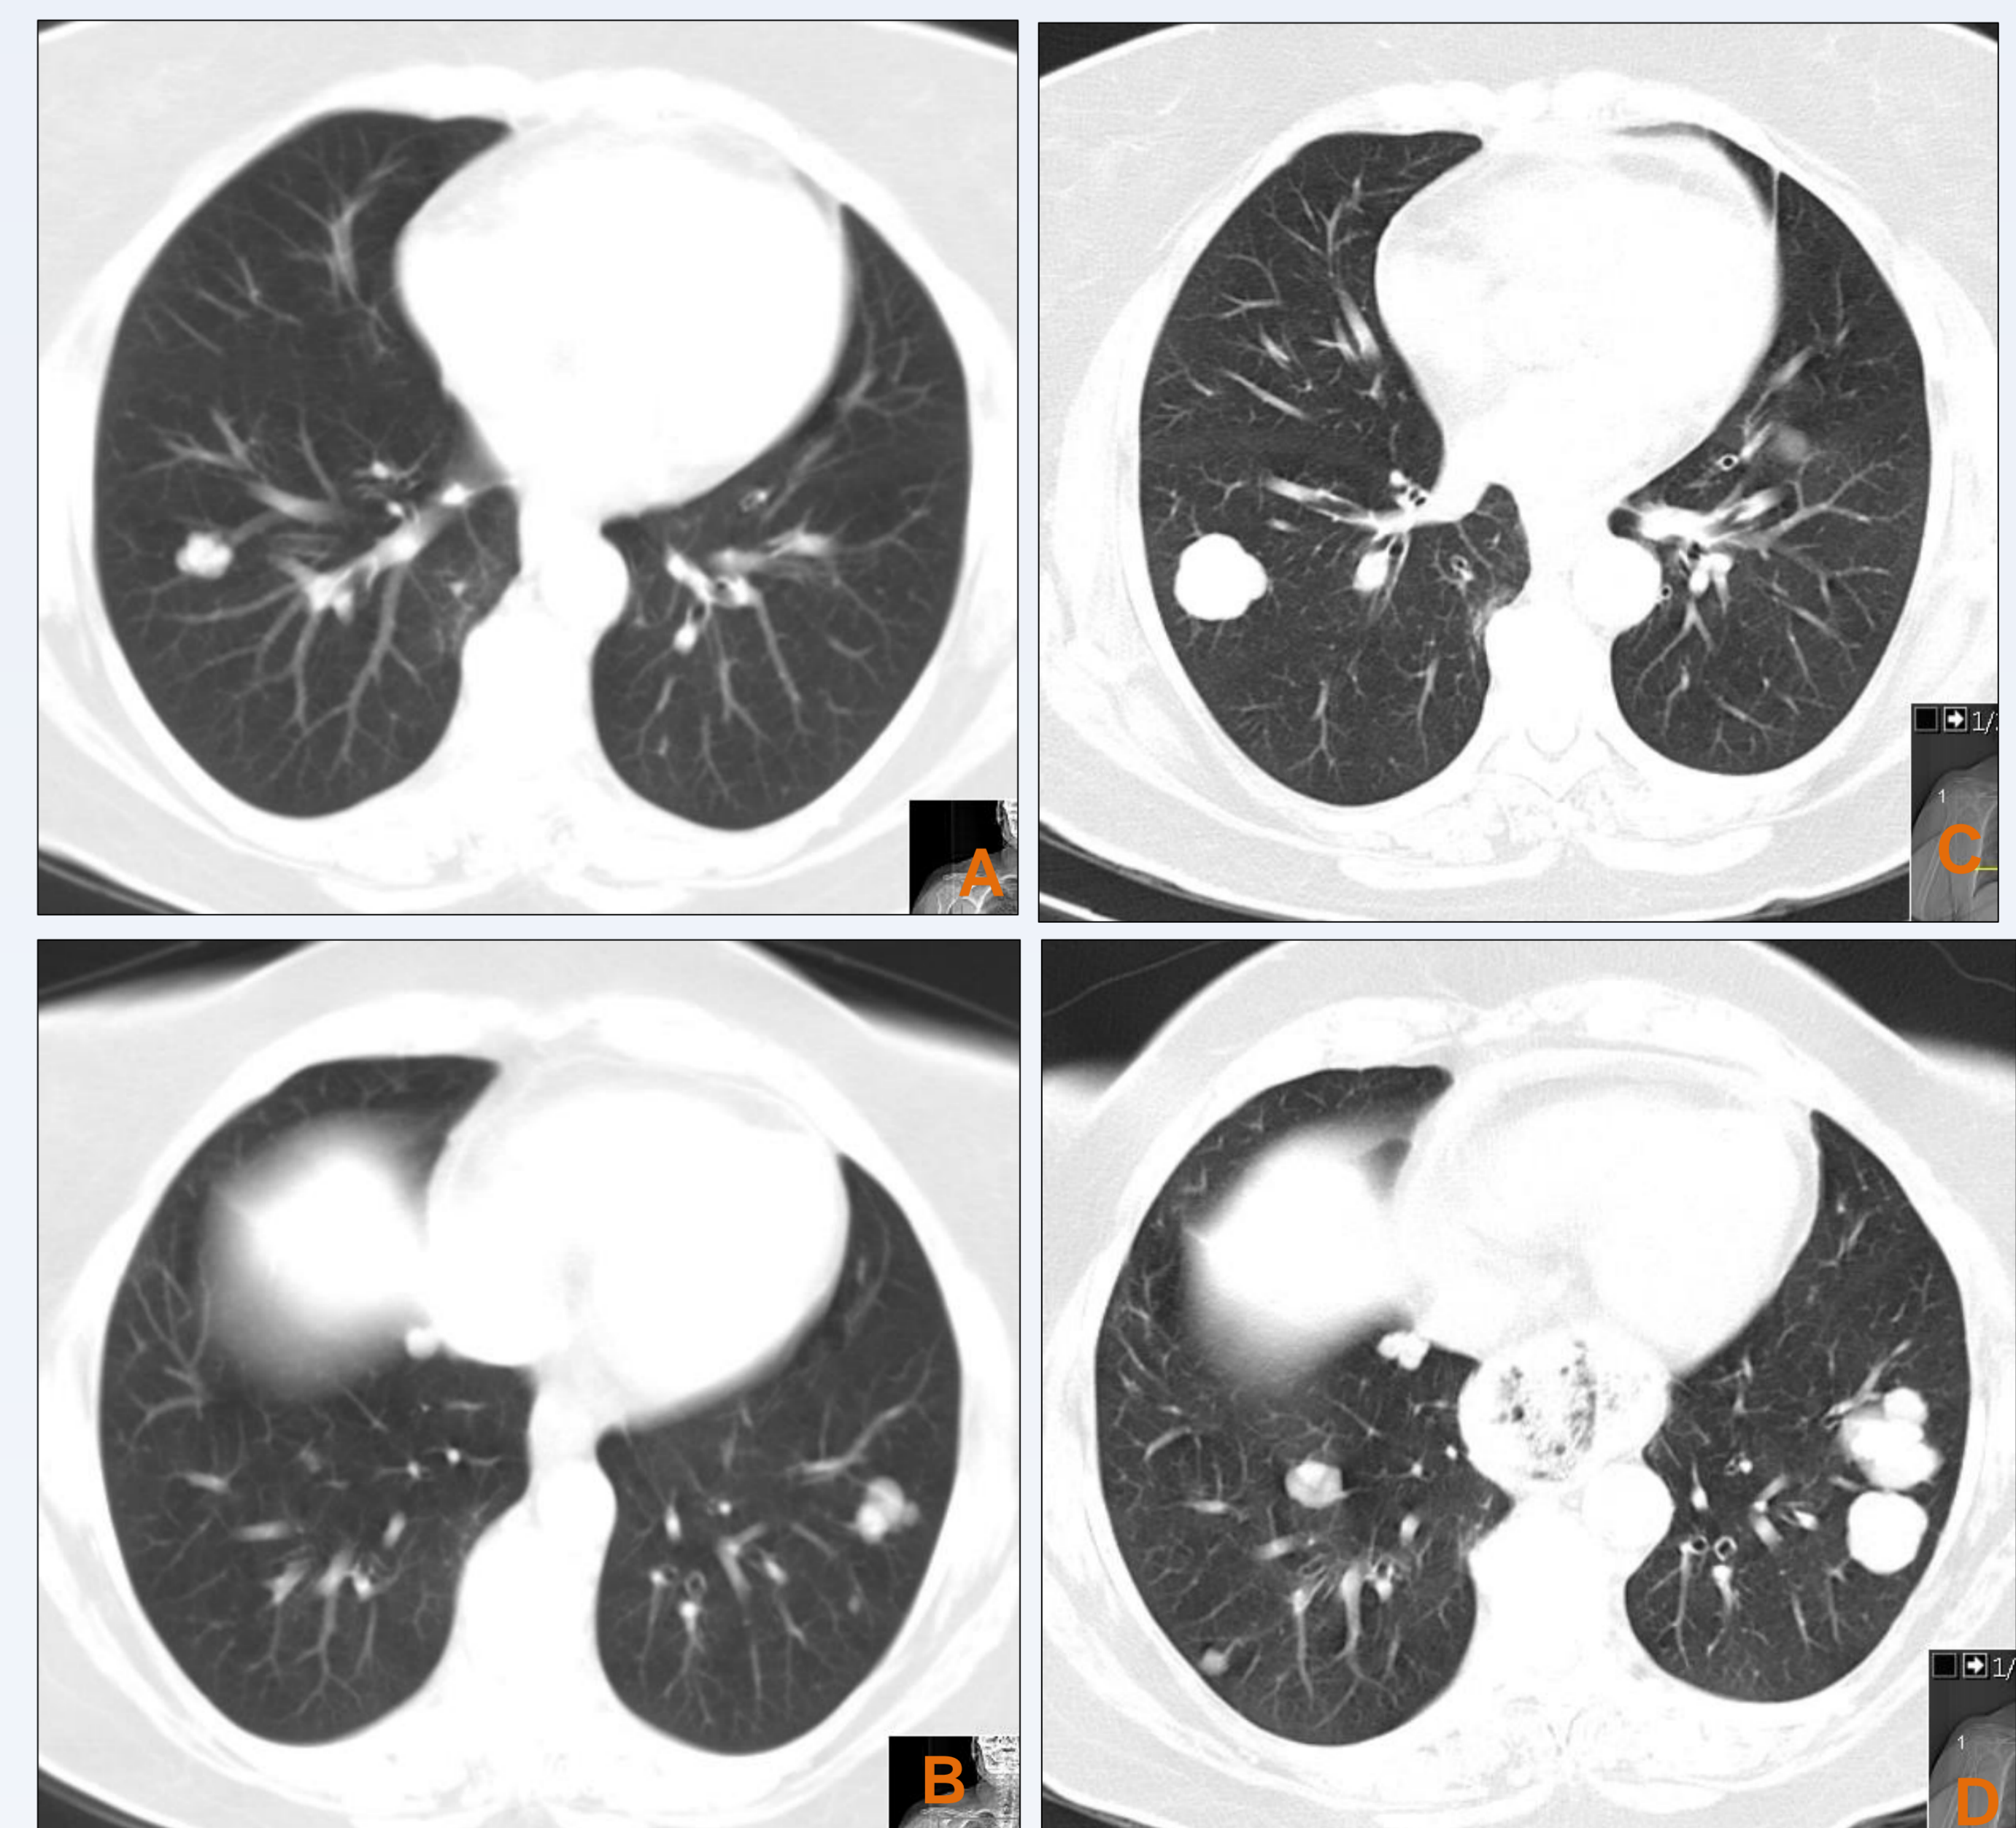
CT evaluation of the lung secondary lesions, at diagnosis (A,B) and 13-years after (C,D).
